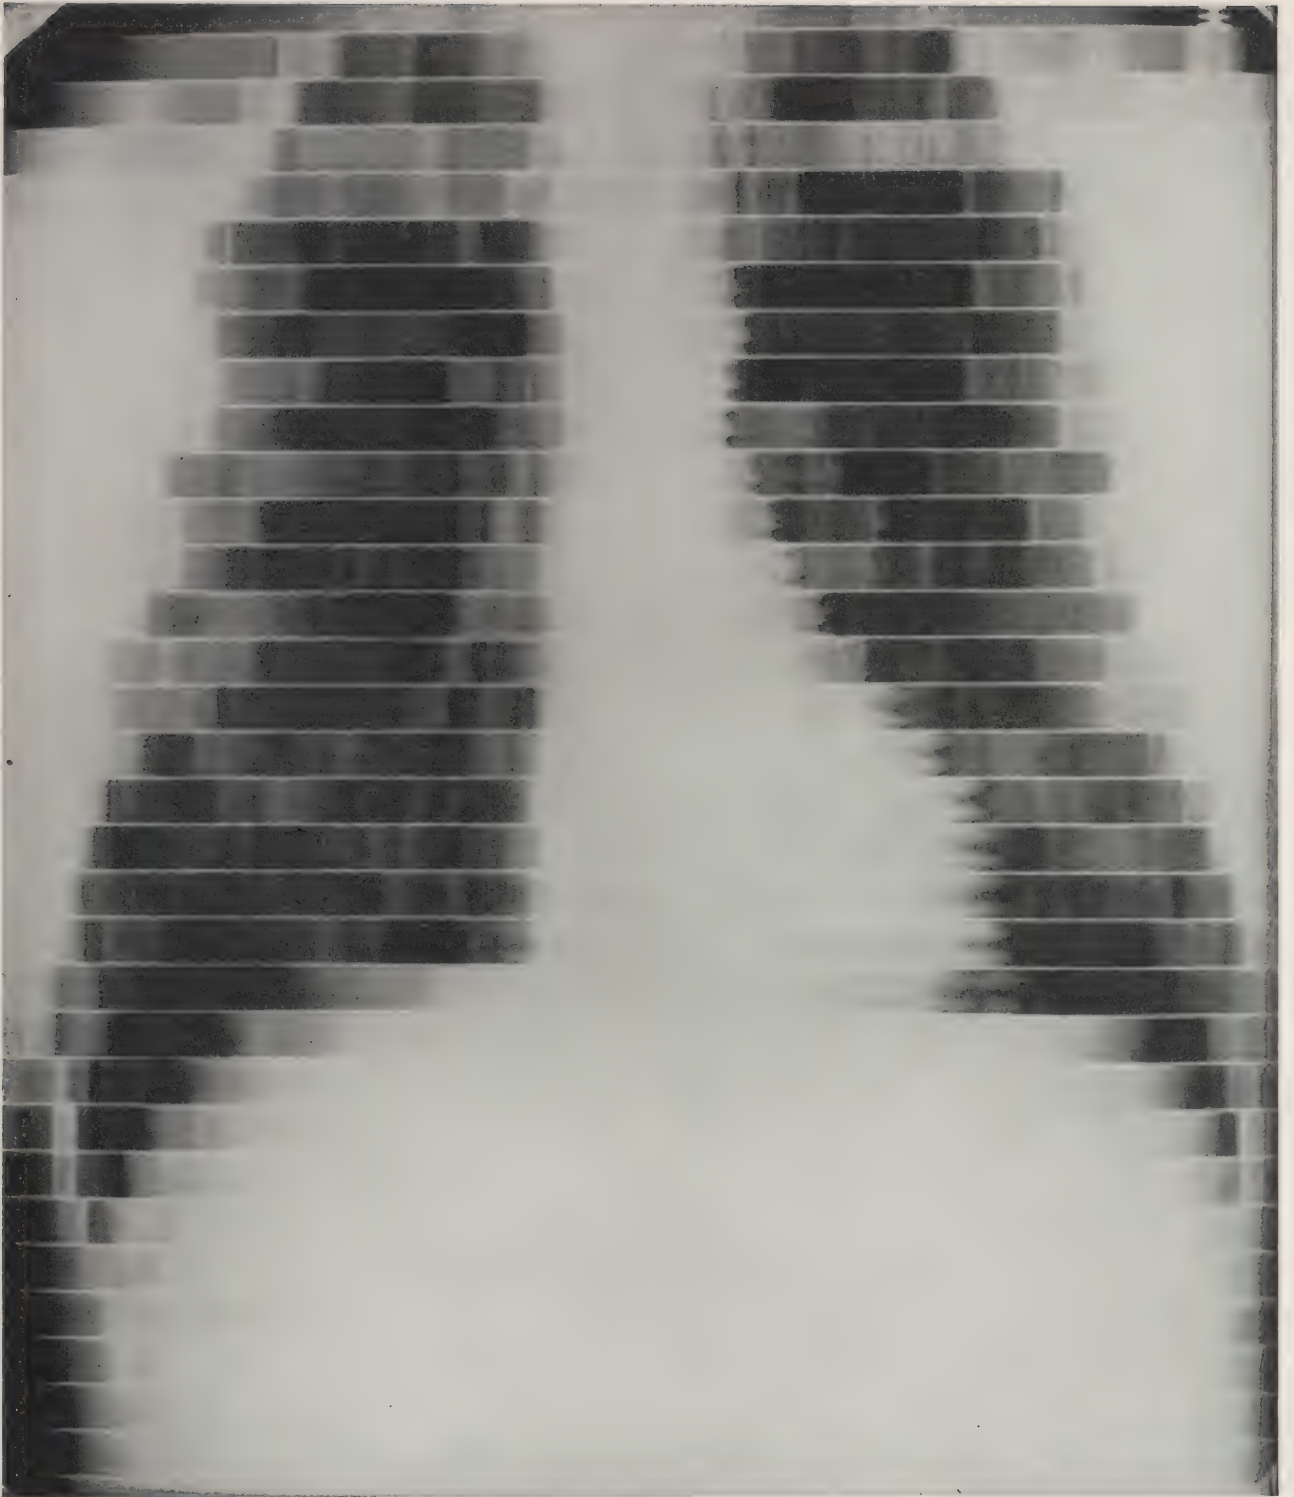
Roentgen kymogram.
